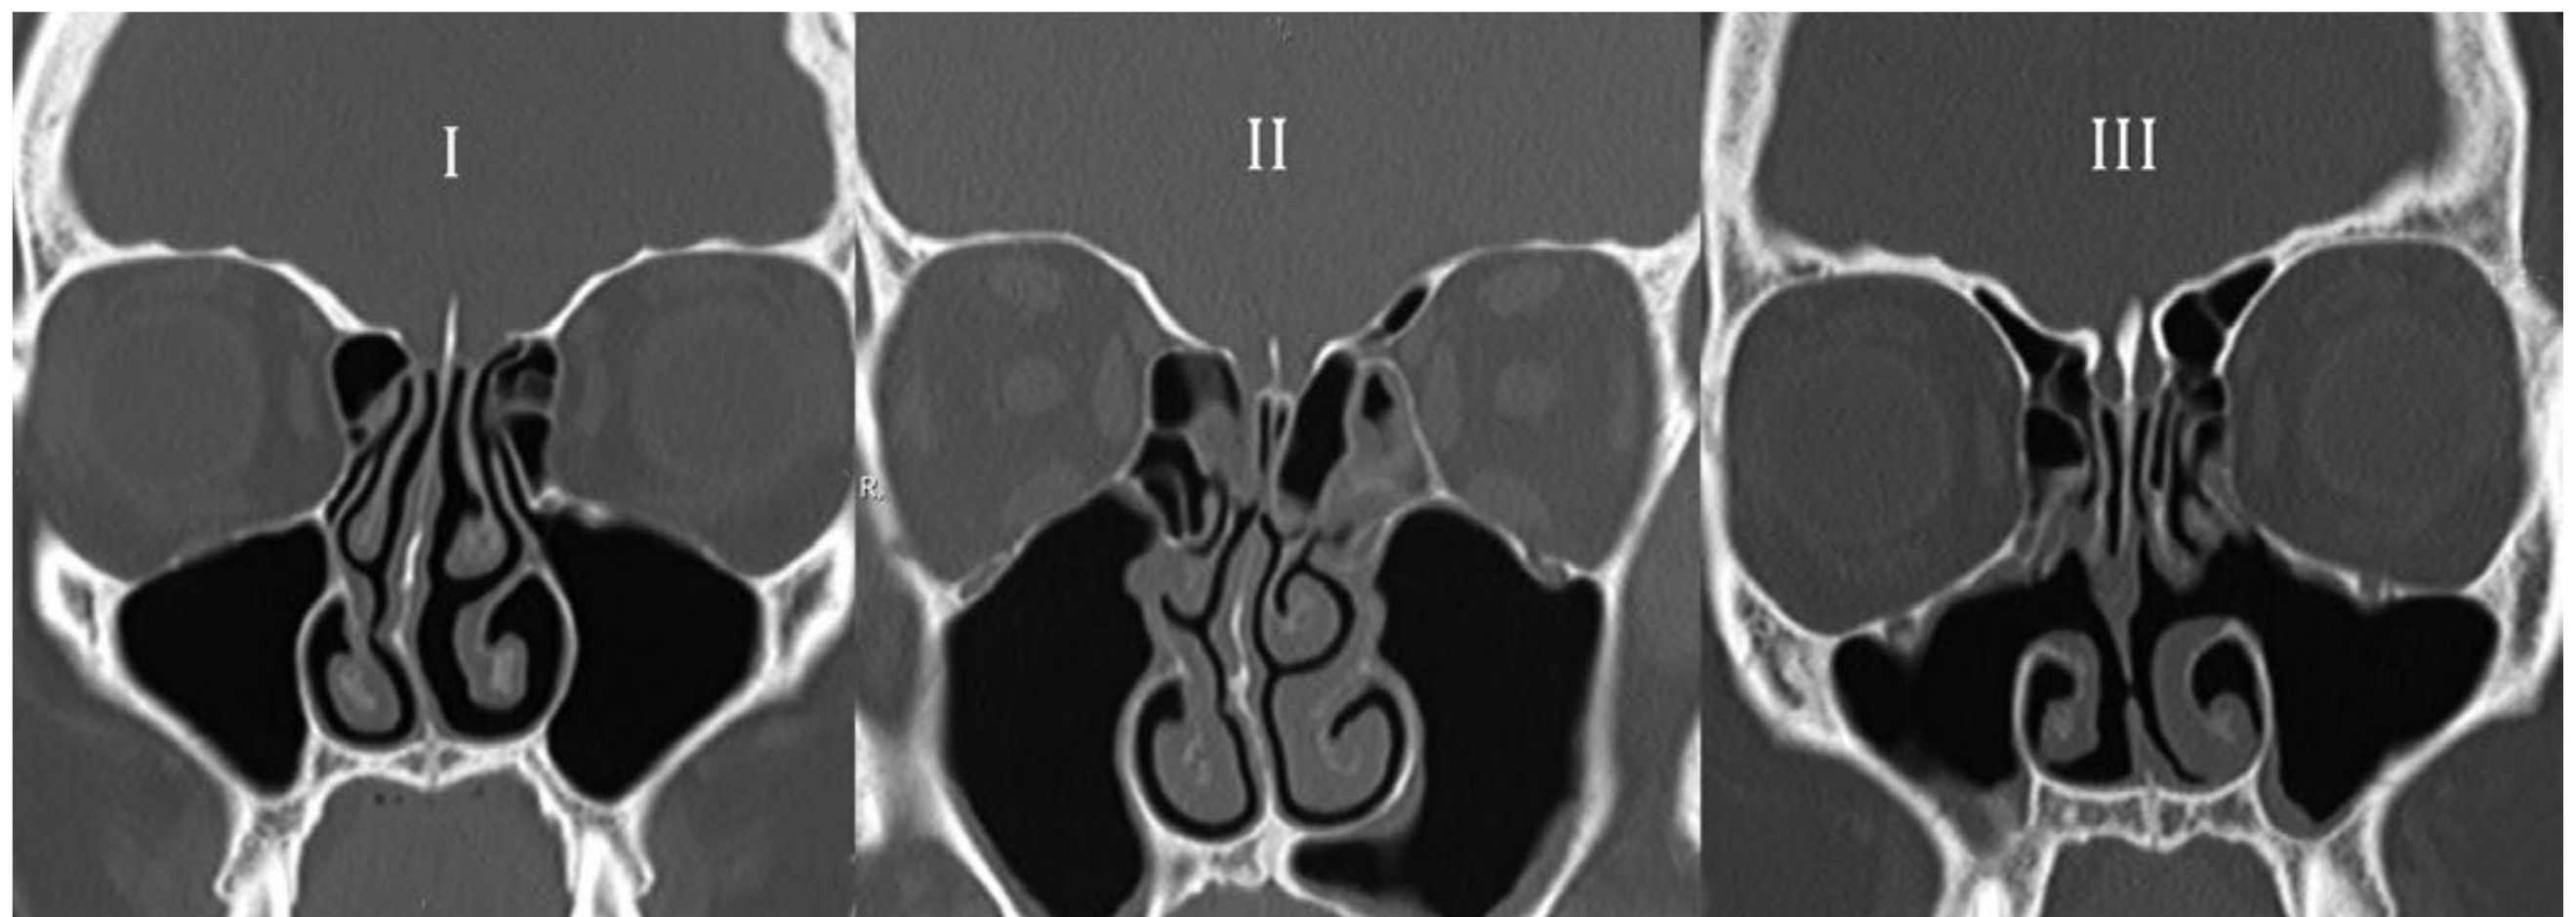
Coronal computed tomography images in three different patients depicts the variable depth of the olfactory fossa, corresponding to the Keros classification, I–III. The image on the left shows a depth
